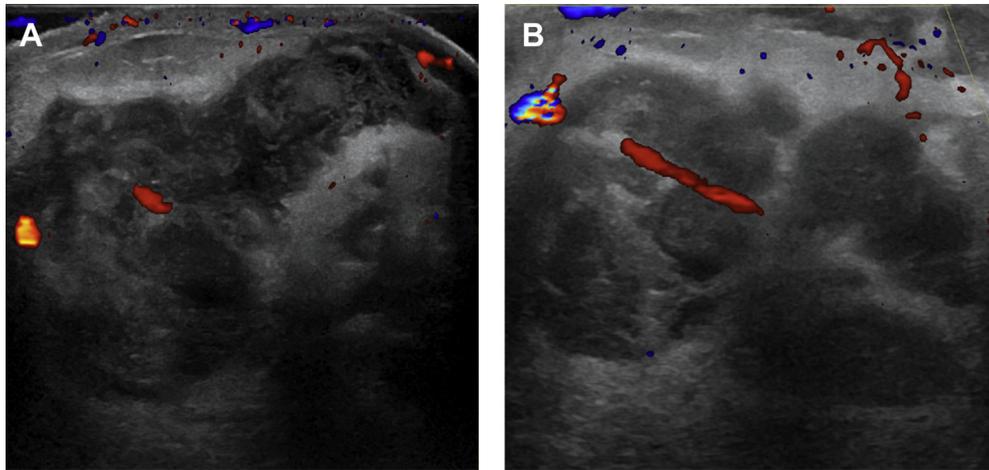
Diagnostic ultrasound images of a 38-year-old female with poorly defined right breast mass with pain and swelling. The imaging shows multiple ill-defined hypodense collections with hyperemia throughout the breast tissue in the lower outer quadrant.
